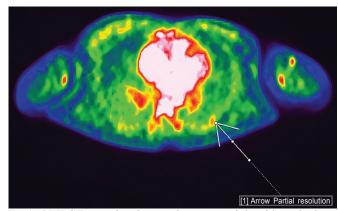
PET CT scan showing a pulmonary nodule with cavitation
